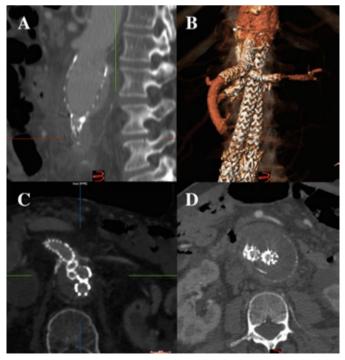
Preoperative CTA of a patient with failed EVAR (Panel A, Endoleakla). The patient was treated with a triple chimney and a Nellix device (Panel B & C). ChEVAR resolved the endoleak as presented in the post-operative CTA (Panel D).
